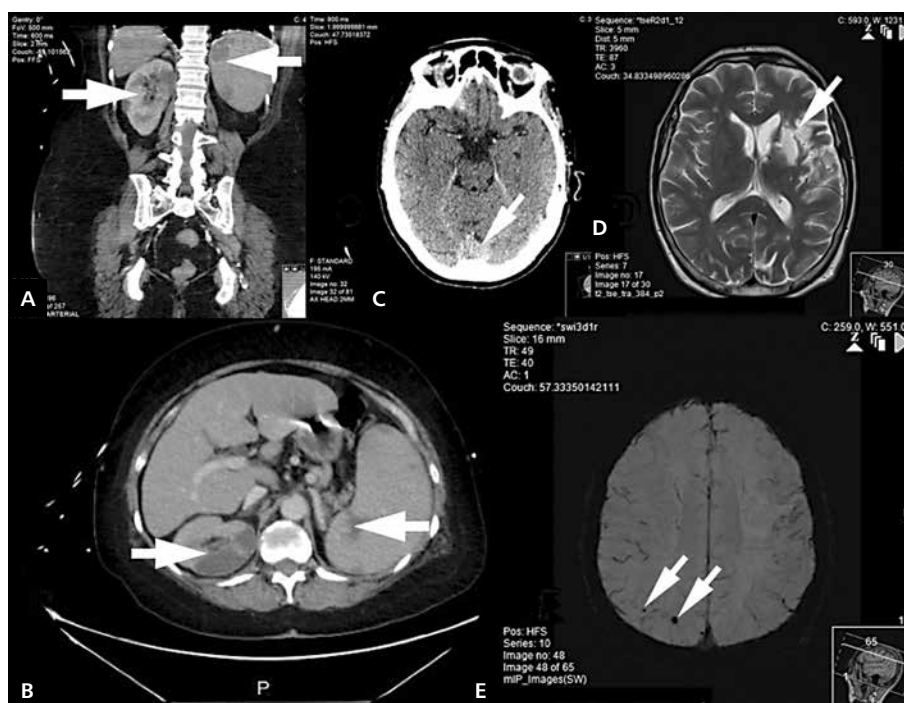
A, B. Computed tomography (CT) abdomen: spleen and kidney emboli secondary to infective endocarditis (arrows); C. CT head: occipital cerebral emboli with brain haemorrhage (arrows); D. Head magnetic resonance imaging (MRI): acute ischaemic lesion (arrows); E. Head MRI: multiple cortical and subcortical microbleeds (arrows)
